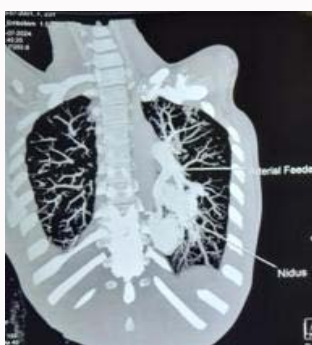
CT Pulmonary angiogram showing left Lower lobe PAVM.
